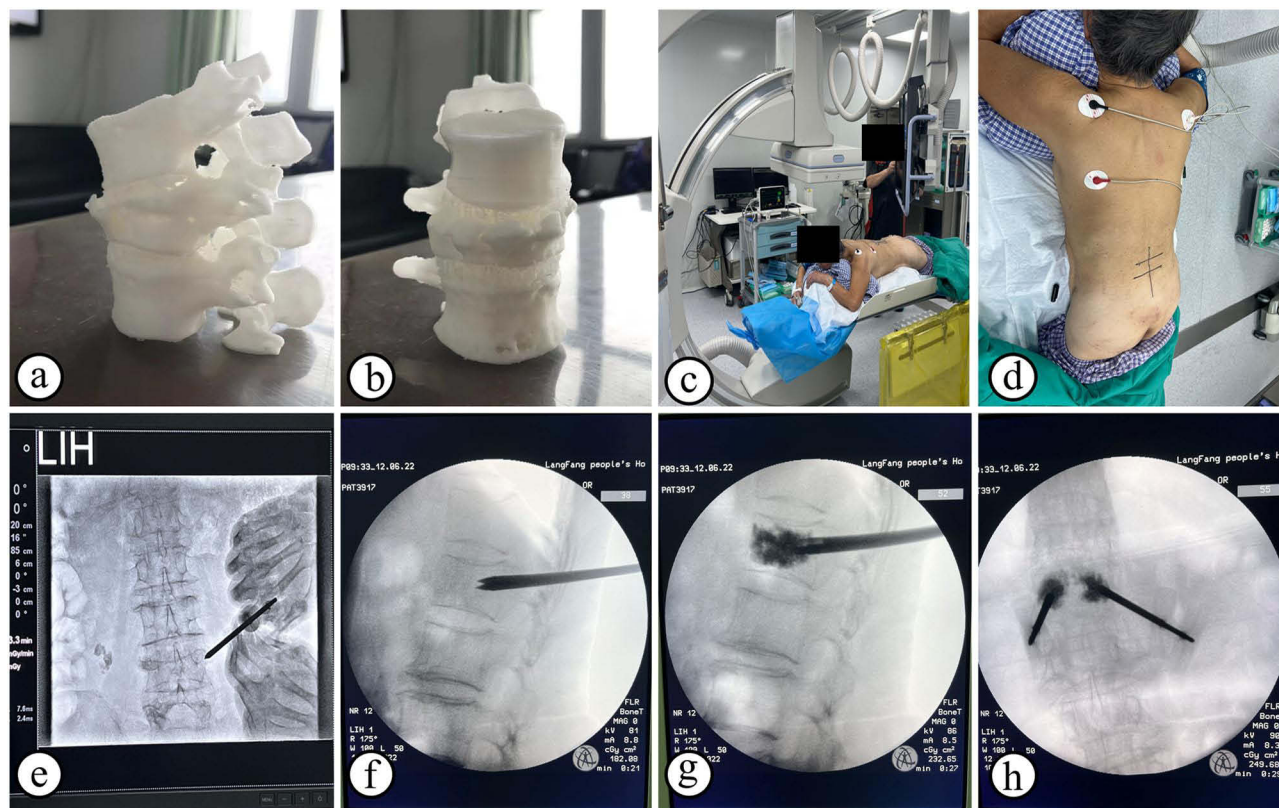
Clinical application of 3D-printing guided PVP. (a and b) The 3D printed model of the fractured vertebra. (c and d) CT images were taken and the optimal needle trajectory and entry points were marked. (e and f) A 13-gauge bone needle was inserted into the pedicle of the fractured vertebra under fluoroscopic guidance. (g and h) The bone cement was injected into the fractured vertebra under fluoroscopic guidance.
